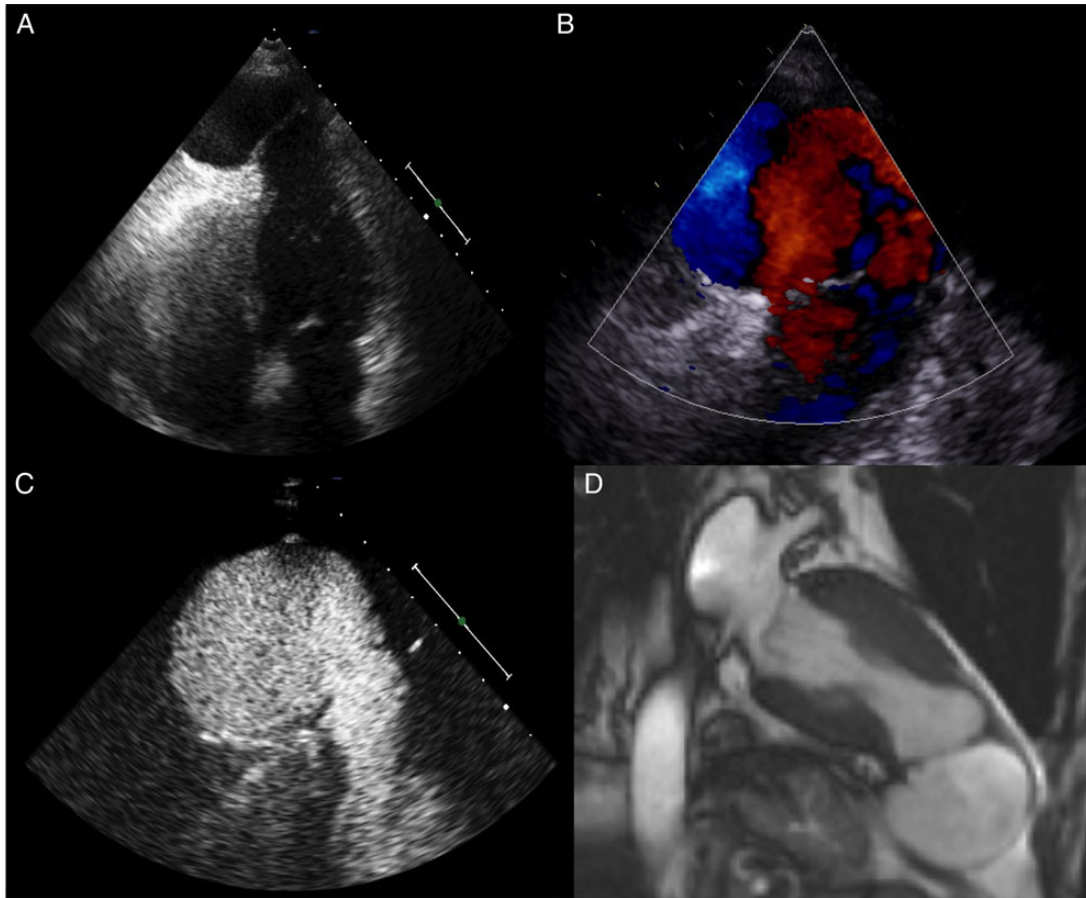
(A) Transthoracic echocardiogram; four-chamber view. (B) Colour Doppler showing bidirectional flow of blood within the left ventricular pseudoaneurysm. (C) Contrast-enhanced transthoracic echocardiogram, zoomed on the left ventricular pseudoaneurysm. (D) Cardiac magnetic resonance image; vertical long-axis view of the heart.
